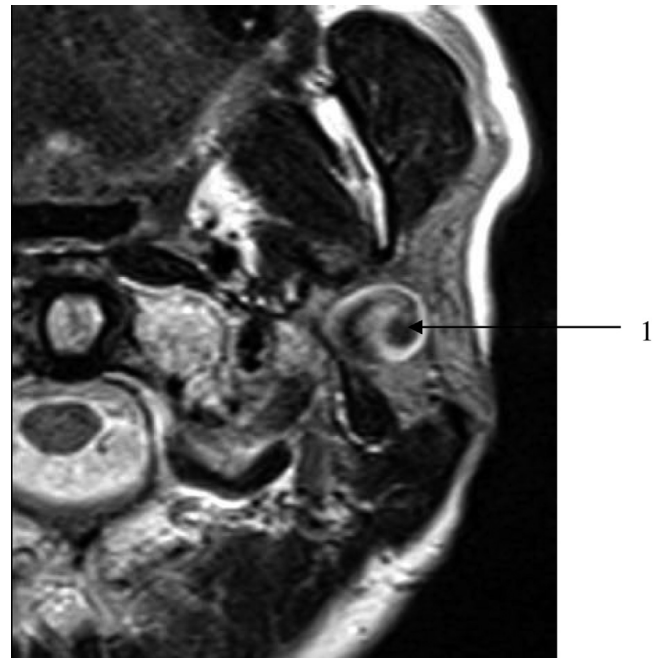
MRI T2 transverse section: visualisation of hyperintense arterial blood flow within a T2-hypointense mass (1).
